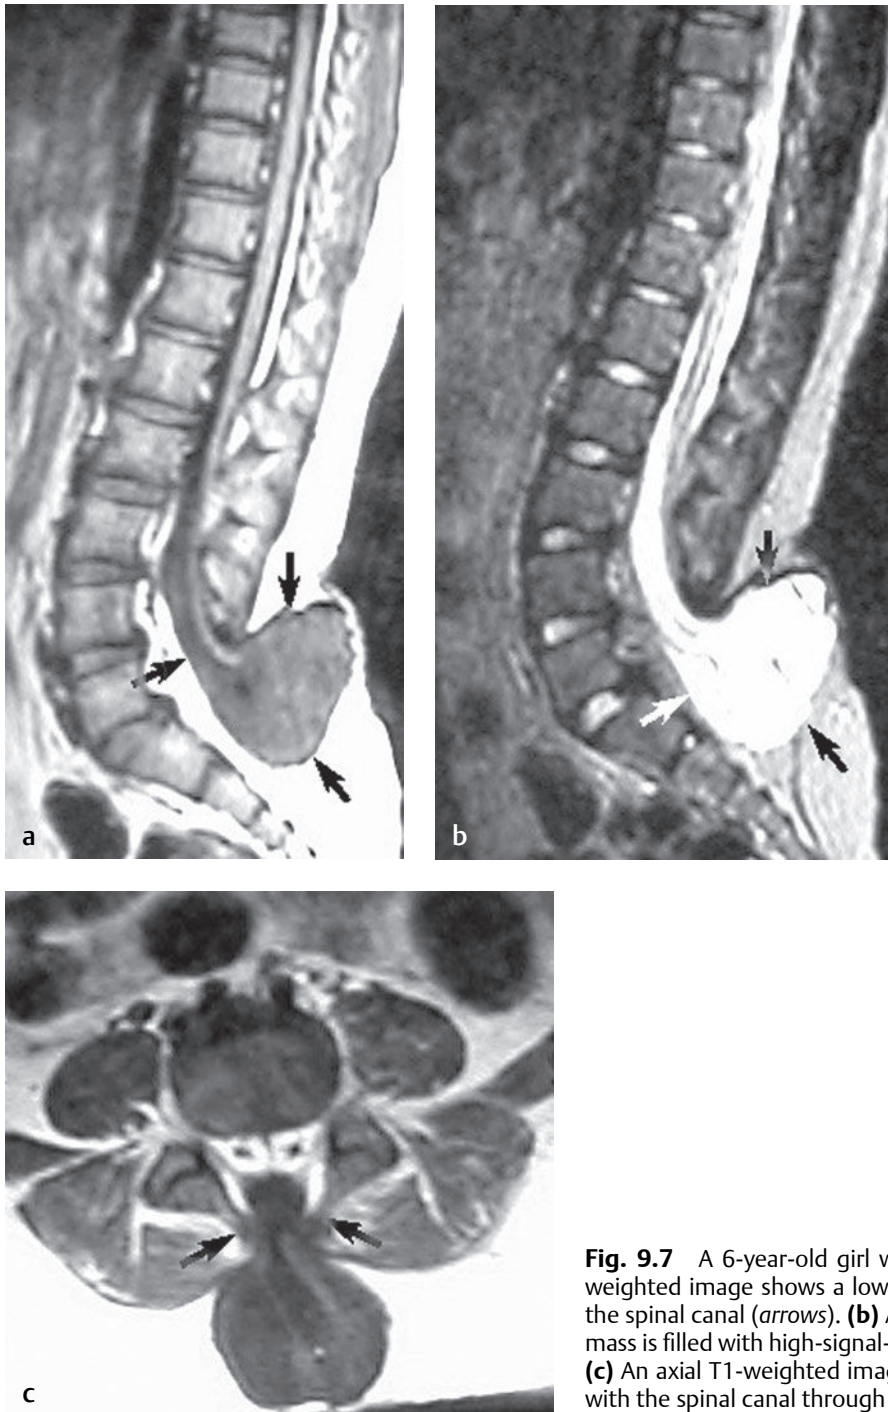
A 6-year-old girl with a myelomeningocele. (a) A sagittal T1-weighted image shows a low back mass contiguous with the contents of the spinal canal (arrows). (b) A sagittal T2-weighted image shows that the mass is filled with high-signal-intensity fluid, compatible with CSF (arrows). (c) An axial T1-weighted image confirms the communication of the mass with the spinal canal through a defect in the posterior elements (arrows).
